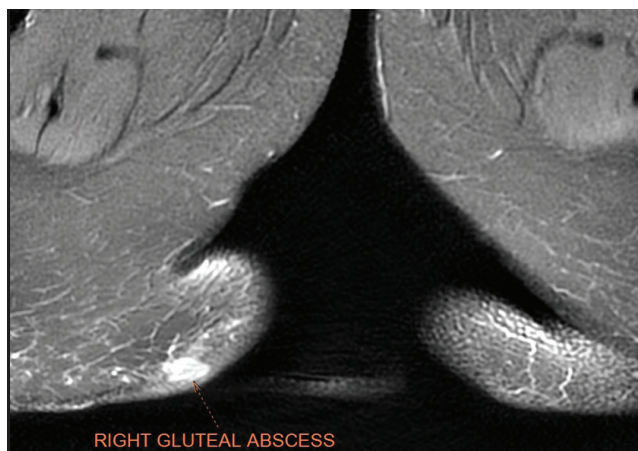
MRI shows right gluteal abscess
